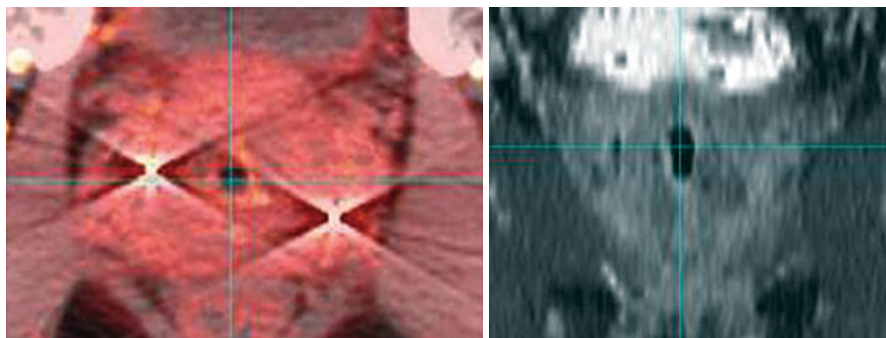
Prostate fiducials as seen on CT-based (*L panel*) and MRI-based (*R panel*) images: Note fiducial prominence and streak artifact on the CT image, with comparatively less prominence and no artifact on the MRI image
